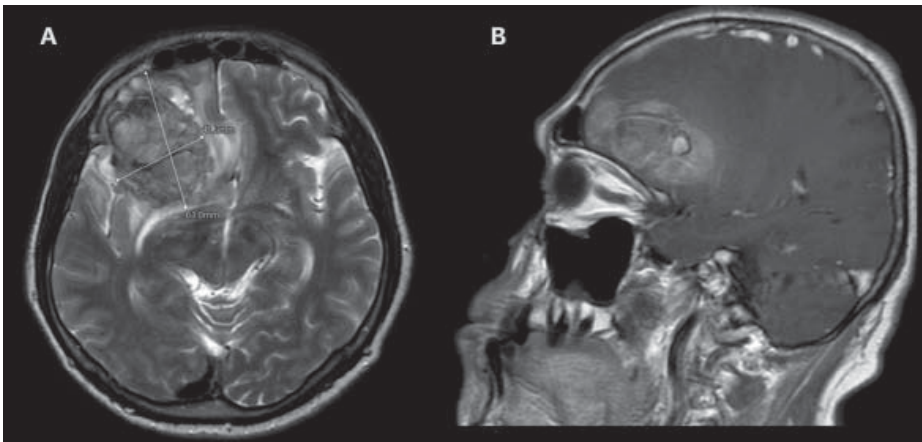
MR image of the 63 x 41 mm mass in the right frontobasal area.
